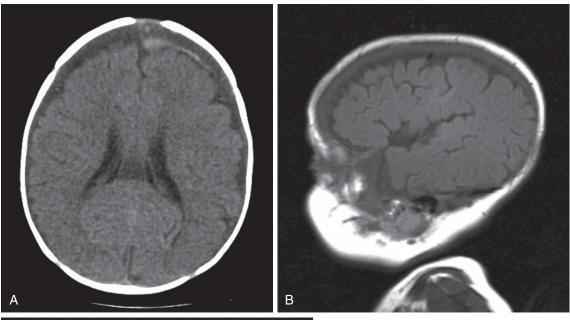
Glutaric aciduria type 1. This 3-month-old infant was brought to the emergency department with complaints of being limp and unresponsive with a recent history of pneumonia. The initial history given was that while alone with his father, he had suddenly become lethargic, his eyes had rolled back, and he had stopped breathing for a few seconds. Lethargy resolved soon after arrival. A, A head CT obtained because retinal hemorrhages were found revealed diffuse acute and subacute/ chronic subdural hemorrhages over the convexities in the frontotemporal areas, as well as more acute collections along the posterior interhemispheric fissure and over the right frontal area. B and C, On MRI large acute on chronic subdural hemorrhages were confirmed, along with early signs of atrophy including mild flattening of the gyri, sulcal widening, and mild ventricular enlargement. This prompted testing for possible glutaric aciduria, which was positive in results obtained 1 week later. Interestingly, in the interim, the father acknowledged having shaken the baby after he didn't feed well, whereupon he went limp.
